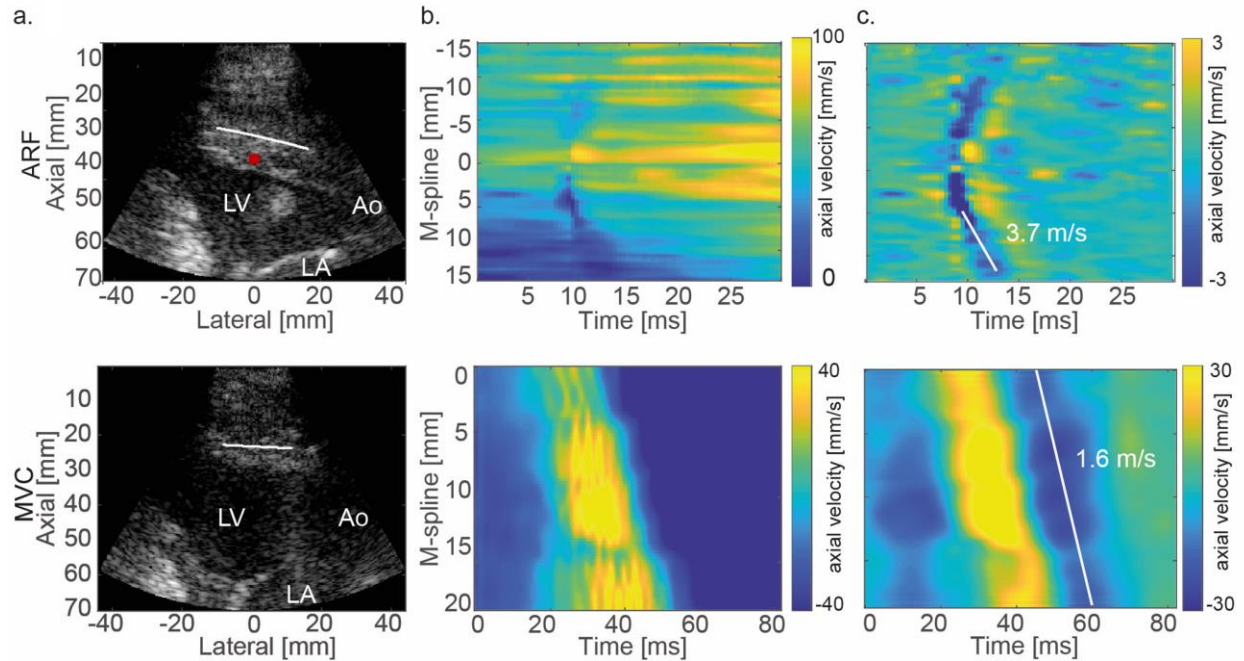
Reconstruction of shear wave speed. (a) B-mode in parasternal long-axis view for acoustic radiation force (ARF) induced shear waves in the upper panel (red rectangle indicates push focus) and shear waves induced by mitral valve closure (MVC) in lower panel. (b) Measured tissue motion. (c) Measured shear wave motion after application of band pass filter with cut-off frequencies at 75-750 Hz for ARF-induced wave and 15-100 Hz for MVC-induced wave. For ARF-based SWE, two shear waves are created in the center of the field of view (in the IVS); whereas for natural SWE one shear wave is propagating from base to apex. Adapted with permission from Keijzer and Caenen et al. (33).
